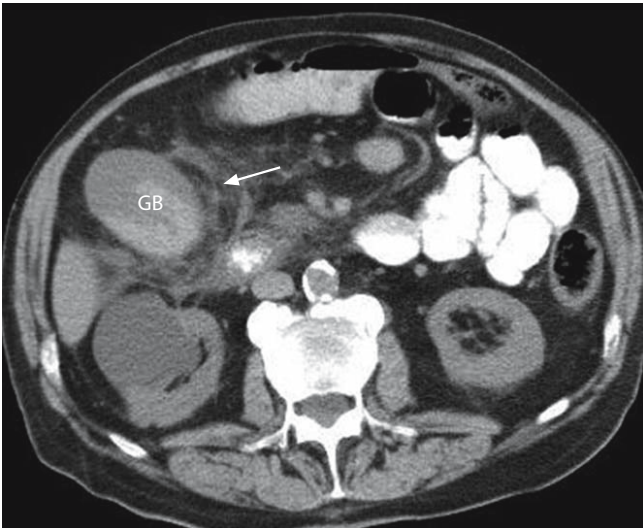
CT scan through the upper abdomen shows a distended thick walled gallbladder (GB) with marked pericholecystic stranding (*arrow*) suggestive of acute cholecystitis
